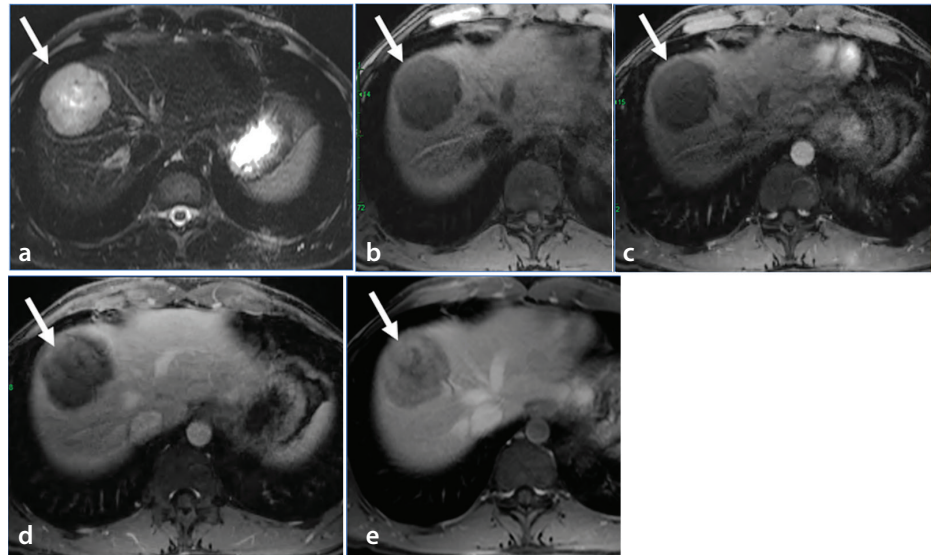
Schwannoma. Axial T2-weighted imaging with fat suppression (a) and dynamic post-gadolinium T1-weighted imaging with fat suppression (b-e) show a right hepatic lobe mass (arrows). The mass demonstrates high T2 signal intensity, low T1 signal intensity, and progressive enhancement following contrast administration.
